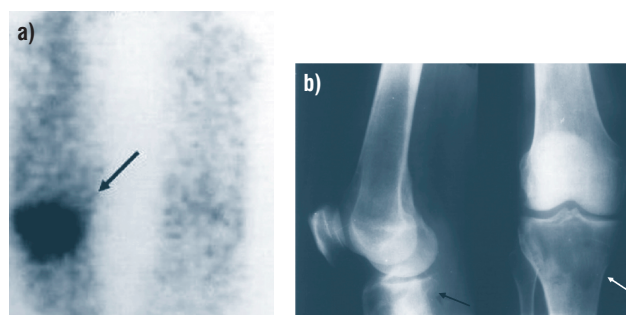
Radioimmunoscyntigraphy in the patient with squamous cell carcinoma of the lung and a distant bone metastasis. a) increased uptake of ^{99m}Tc -HMFG1-MoAb in the right tibia and in the surrounding tissue; b) X-ray of right knee showed large osteolytic lesion in the right tibia (black and white arrows).
